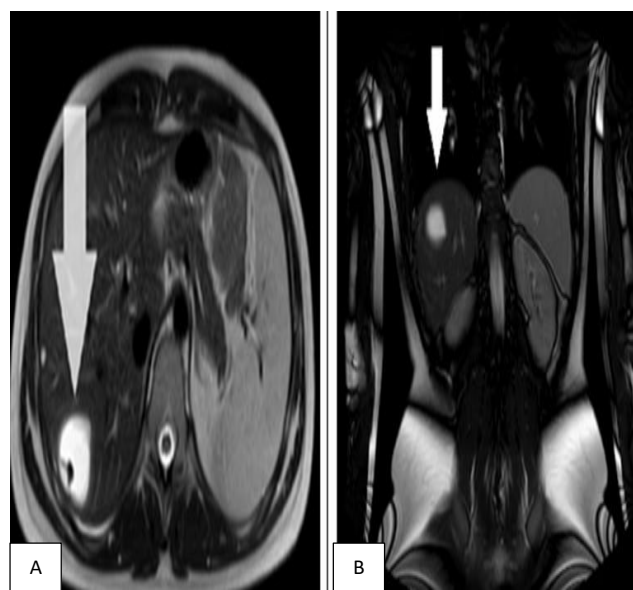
(A and B): MRI-scan of the abdominal cavity.
